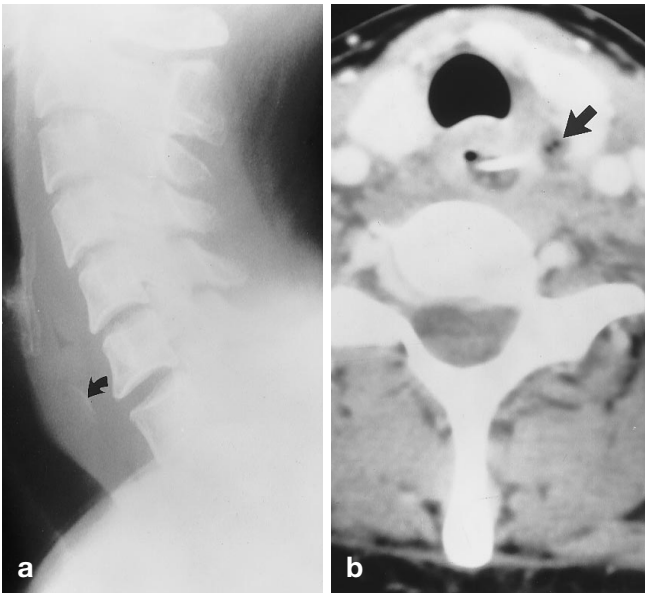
A 40-year-old woman presented to the emergency room complaining of dysphagia after eating fish for dinner. a A lateral plain film of the neck demonstrates thickening of the lower cervical prevertebral/retropharyngeal tissues. A questionable abnormal curved density is noted (*arrow*). b A contrast-enhanced CT scan in the same patient confirms the presence of a foreign body which has penetrated the wall of the esophagus. A small gas and fluid collection is noted adjacent to the esophagus (*arrow*), consistent with abscess formation. At surgery, this collection was drained and a fish bone was removed from the esophagus
